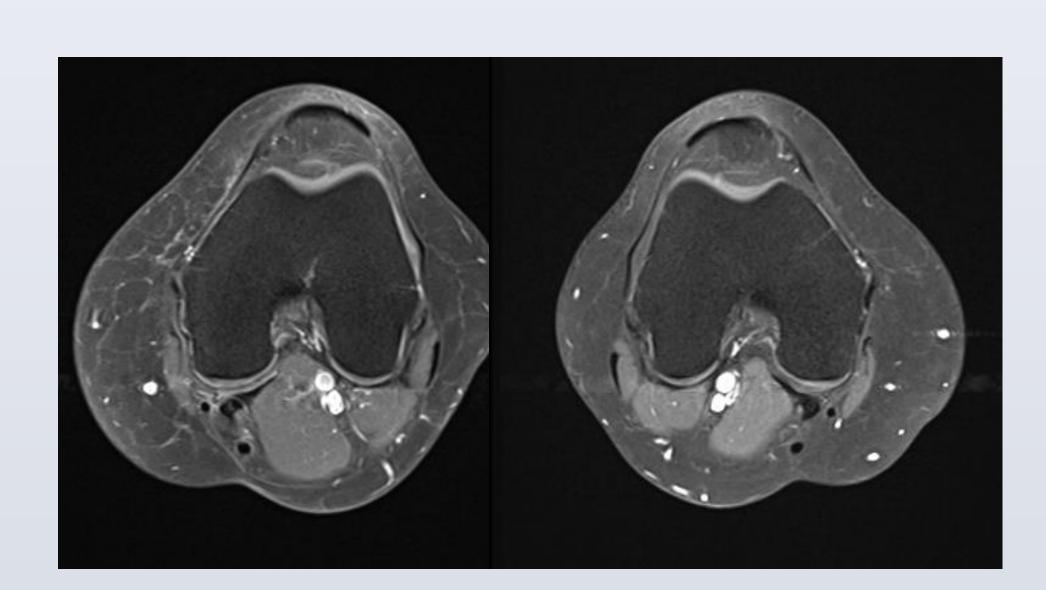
MRI demonstrating normal anatomic course of bilateral popliteal
